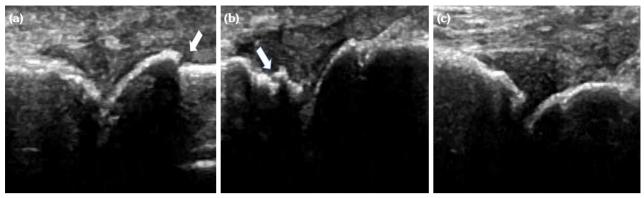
Two-dimensional ultrasound images (representative) of SNRA, SPRA, and non-RA. (a) A 45-year-old male patient diagnosed with SNRA; two-dimensional ultrasonography showed Grade 2 synovial hyperplasia and Grade 2 bone erosion (indicated by the arrow); (b) a 55-year-old female patient diagnosed with SPRA; two-dimensional ultrasonography showed Grade 2 synovial hyperplasia and Grade 2 bone erosion (pointed by the arrow); (c) A 67-year-old male patient diagnosed with osteoarthritis; two-dimensional ultrasound showed Grade 1 synovial hyperplasia and Grade 0 bone erosion. SNRA: Seronegative rheumatoid arthritis: SPRA: Seropositive rheumatoid arthritis: RA: Rheumatoid arthritis.
